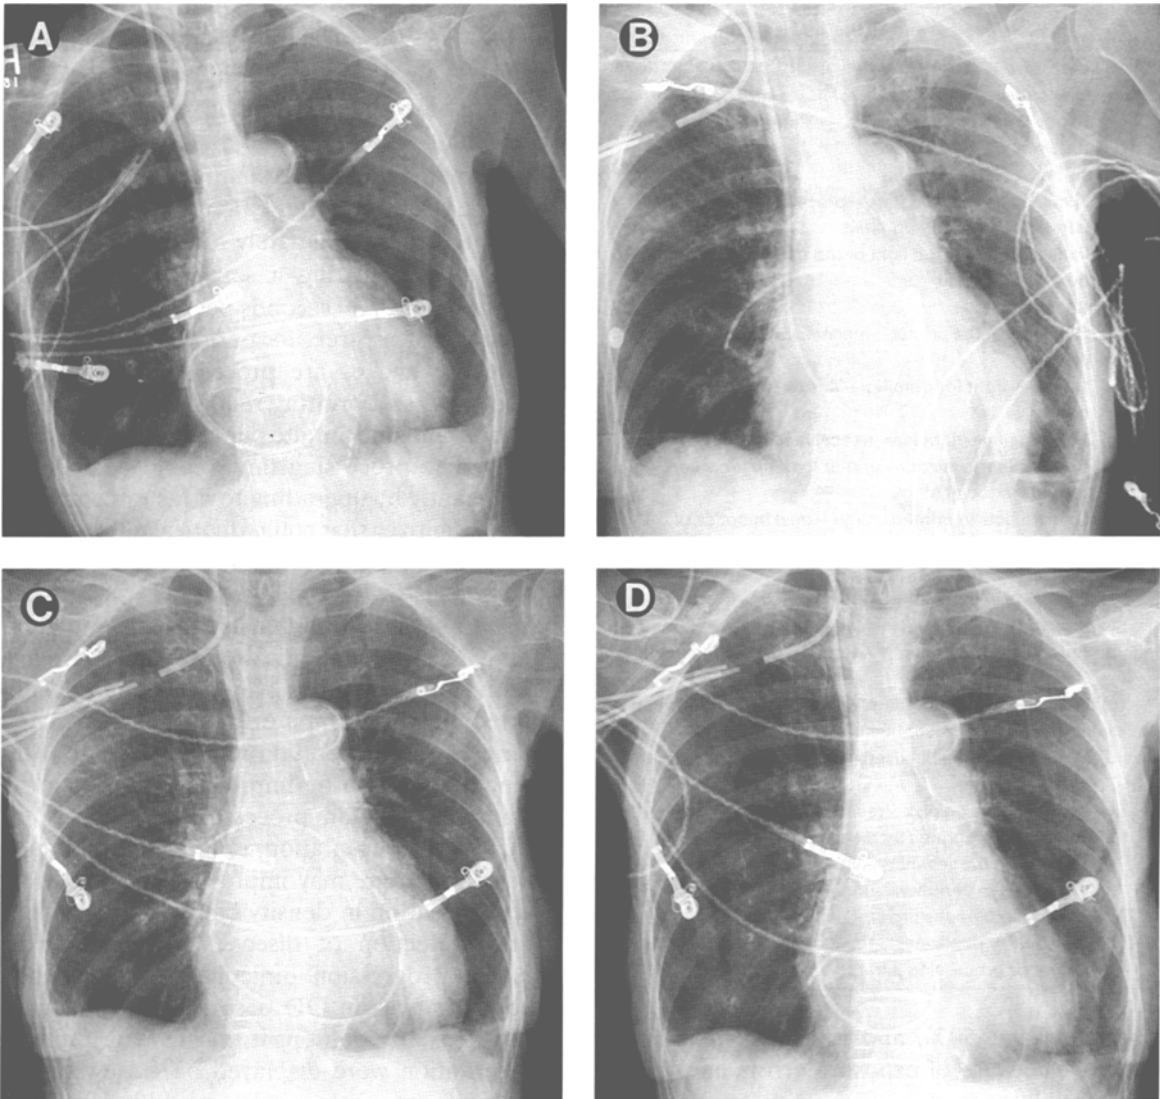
A series of portable chest radiographs of the same patient that includes both digital film duplicates (A and C) and storage phosphor computed radiographs (B and D). We use slightly different processing parameters for film and SPCR images to produce the closest possible visual match for day-to-day comparison.
